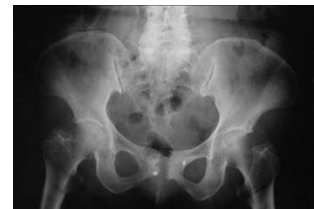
Anteroposterior plain radiograph of the pubis demonstrated 2 bone screws in place, bone sclerosis and irregularity of the margins of the pubic bone.
